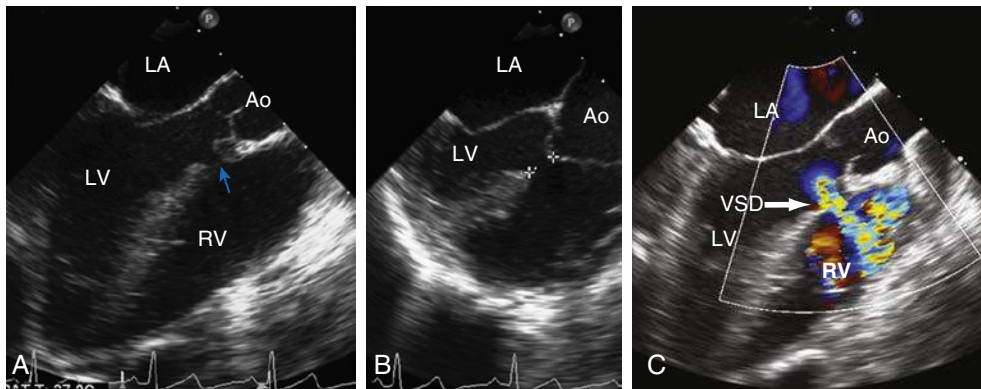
A and B, Two-dimensional transthoracic echocardiogram (2D TTE) permits accurate assessment of the size and spatial relationships of this muscular-outlet VSD. The blue arrow shows the location of the VSD. The + symbols indicate the size of the VSD. C, Color Doppler demonstrates a left-to-right shunt through the VSD (white arrow). Ao, Aorta; LA, left atrium; LV, left ventricle; RV, right ventricle; VSD, ventricular septal defect.
